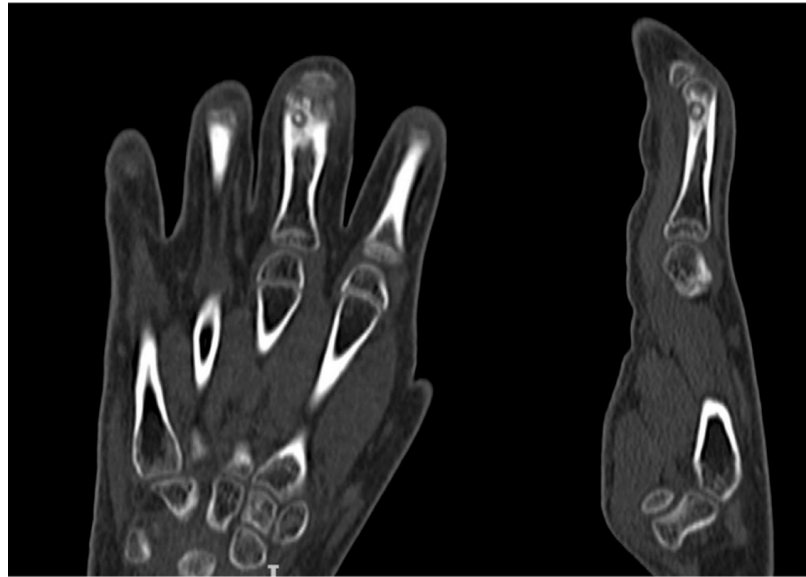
CT images showing a small IAOO within the proximal phalanx of the third finger of the hand.
